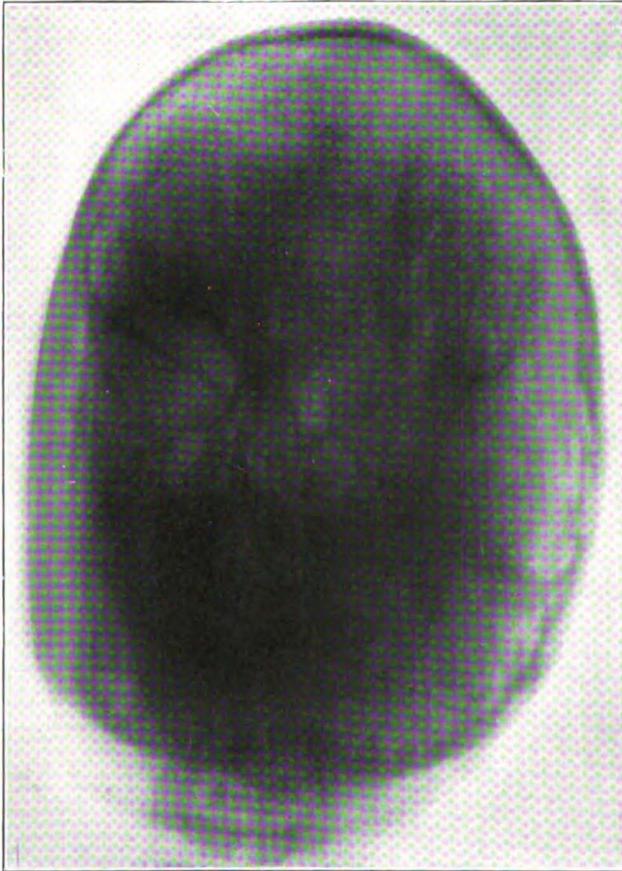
(Case 2).—Roentgenogram of full face, revealing depressions on skull.
